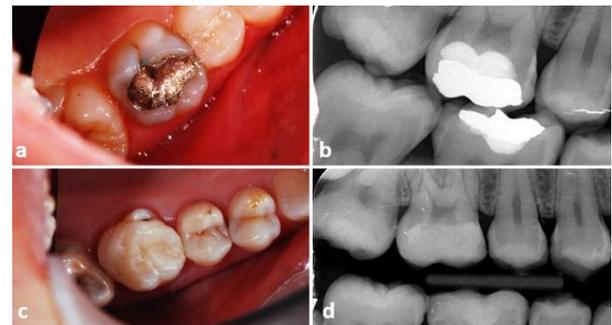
(a) A maxillary right first molar, with caries recurrence on an occlusal amalgam restoration (b) Bite-wing radiograph of the maxillary right first molar (c) 1 year follow-up of IPS e.max indirect restoration (d) Bite-wing radiography of IPS e.max indirect restoration
